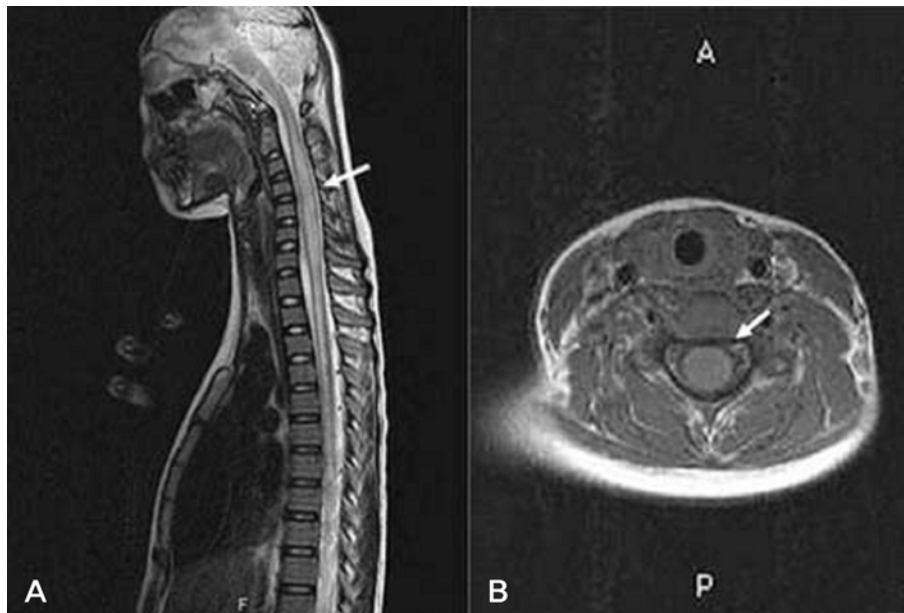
On initial MRI, T2-weighted sagittal image (A) shows a longitudinal view of the intramedullary high signal intensity and fusiform swelling (arrow) extending to the C1-T6 levels. T1-weighted axial image (B) shows an edematous lesion (arrow) of the cord compressing the extramedullary space.
